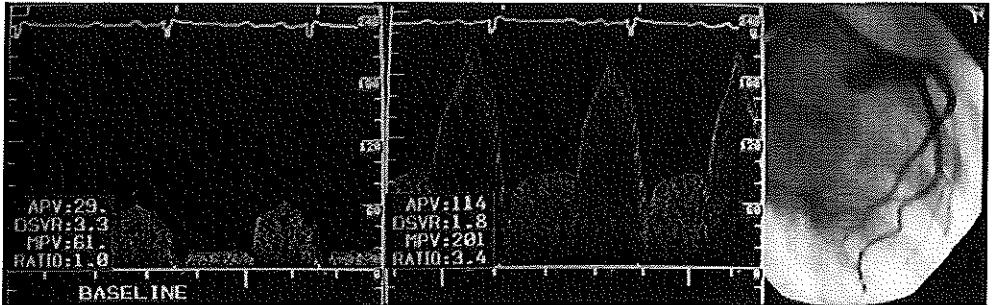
Intracoronary doppler flow measurements at baseline after coil inflation (left panel) and after intracoronary adenosine (middle panel). D3 Infusion catheter in position and during angiogram (right panel). Note good distal perfusion even with catheter fully inflated.
